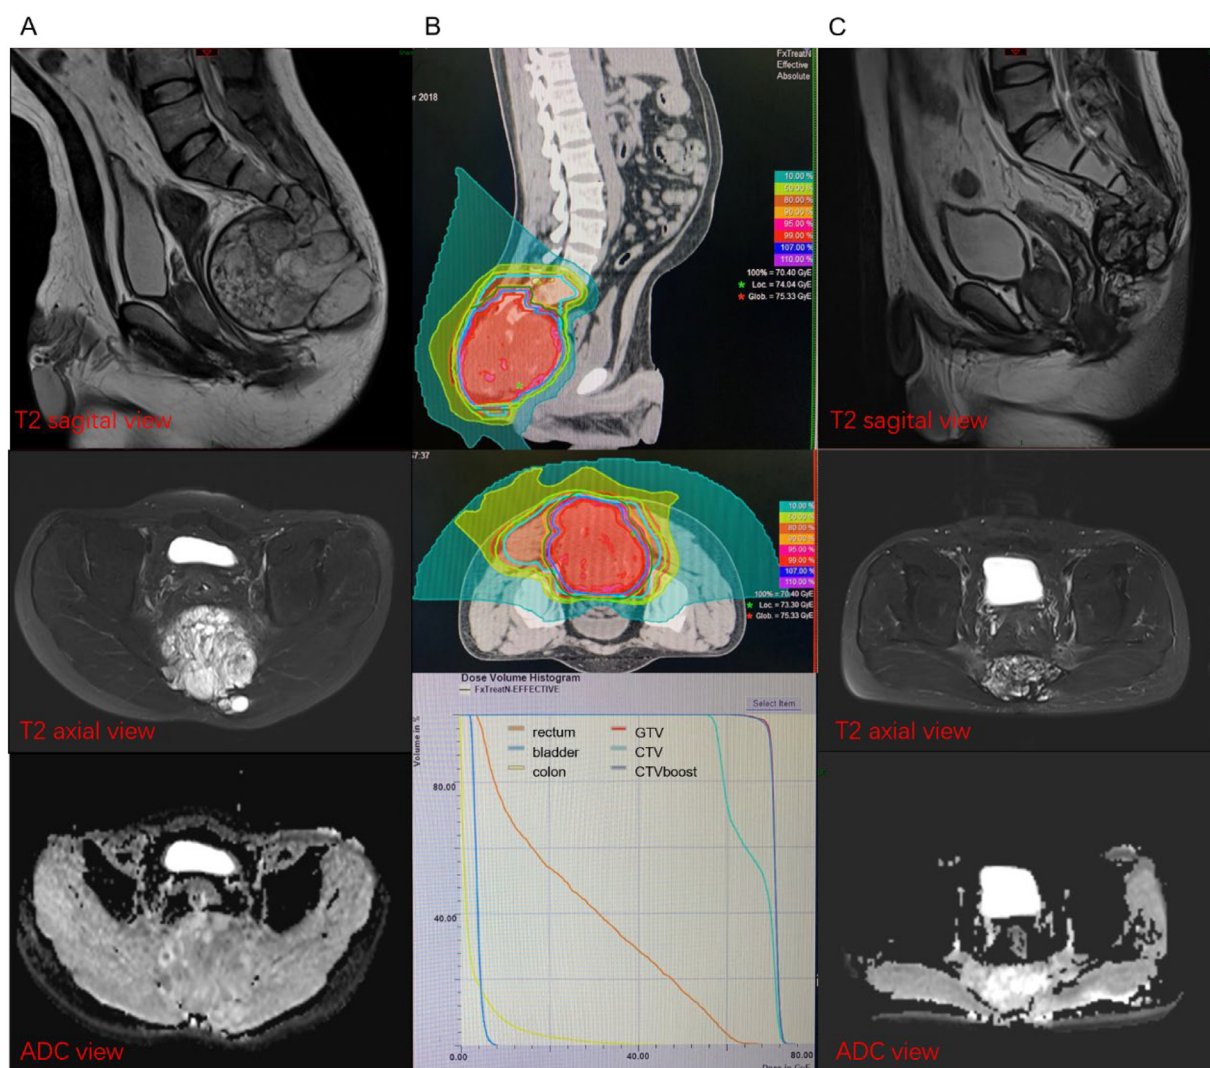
Carbon ion treatment and follow-up magnetic resonance imaging (MRI) of a 36-year-old patient with sacrococcygeal chordoma. (A) Pretreatment MRI. (B) Dose distribution of a carbon ion plan with 70.4 Gy (relative biologic effectiveness) in 16 fractions. (C) MRI of 28 months after treatment, showing marked tumor regression.
